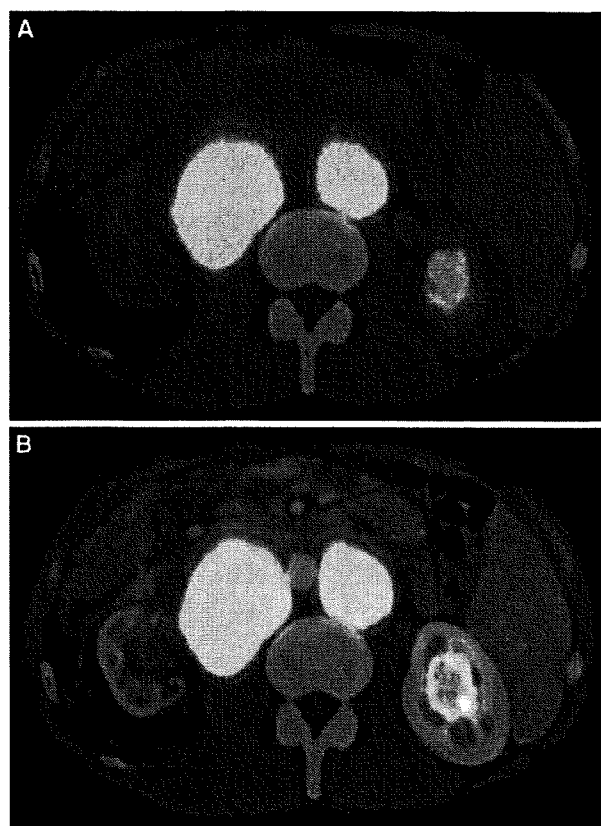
Axial noncontrast PET/CT image (A) and contrast-enhanced PET/CT (B) shows multiple enlarged lumbar lymph nodes with increased uptake in patient with follicular lymphoma. Delineation of the lesion is better on contrast-enhanced PET/CT.
